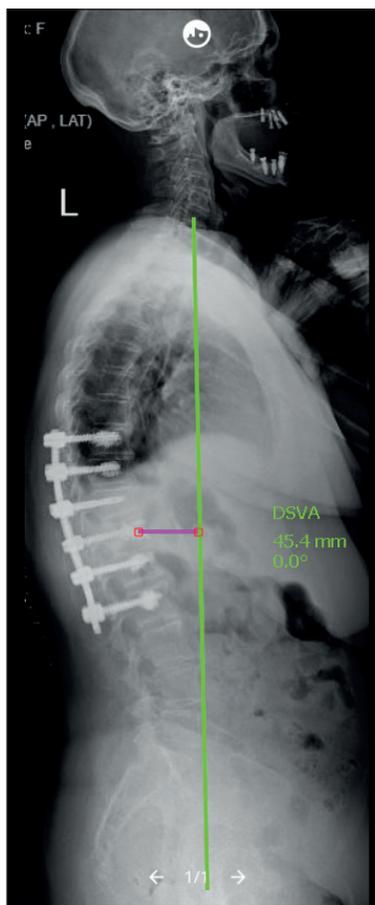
Postoperative lateral spinal radiographs; sagittal balance showed improvement after surgery.
